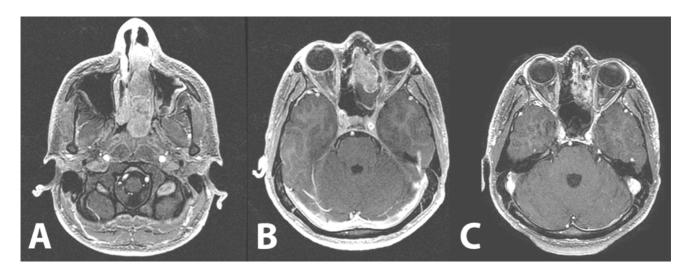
MRI Brain pre and post transsphenoidal resection - Images A and B demonstrate an 8x6x2.4 cm solid mass occupying the left nasal cavity. Image C
